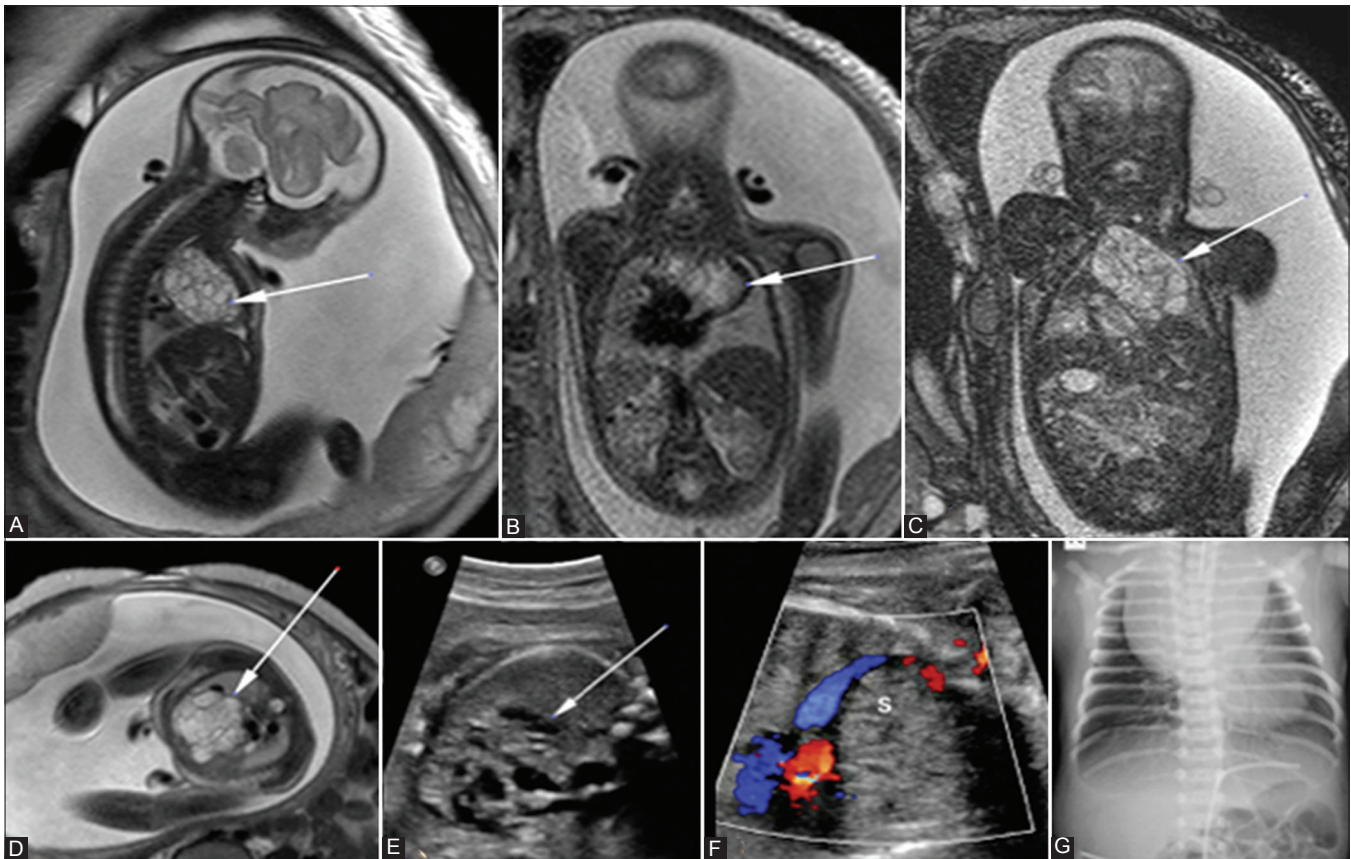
(A-G): Cystic hygroma in a fetus at 31 weeks. T2WI sagittal, (A) and BTFE coronal, (B and C) axial T2WI (D) images showing large multiloculated cystic midline mediastinal mass compressing and displacing the great vessels. Prenatal USG (E and F) revealed multiple cystic lesions in the anterior mediastinum. Postnatal X-ray (G) showed anterior mediastinal widening
